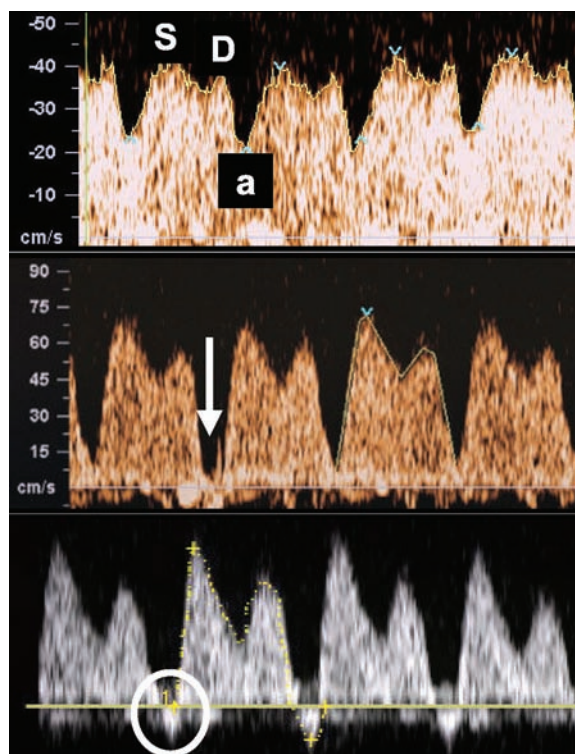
(Top panel) In the venous Doppler waveform systolic and diastolic peaks (the S- and D-waves) are generated by the descent of the AV-ring during ventricular systole and passive diastolic ventricular filling, respectively. A second late diastolic trough after the D-wave is the consequence of sharply increasing right atrial pressures during atrial systole (the a-wave). (Middle panel) With declining forward cardiac function forward velocity during atrial systole (arrow) and to a lesser degree during diastole decreased. This is associated with an increase in venous Doppler indices. (Bottom panel) When ductus venosus Doppler indices escalate, absence or reversal of forward flow during atrial systole (circle) may be observed as the most marked Doppler abnormality.
